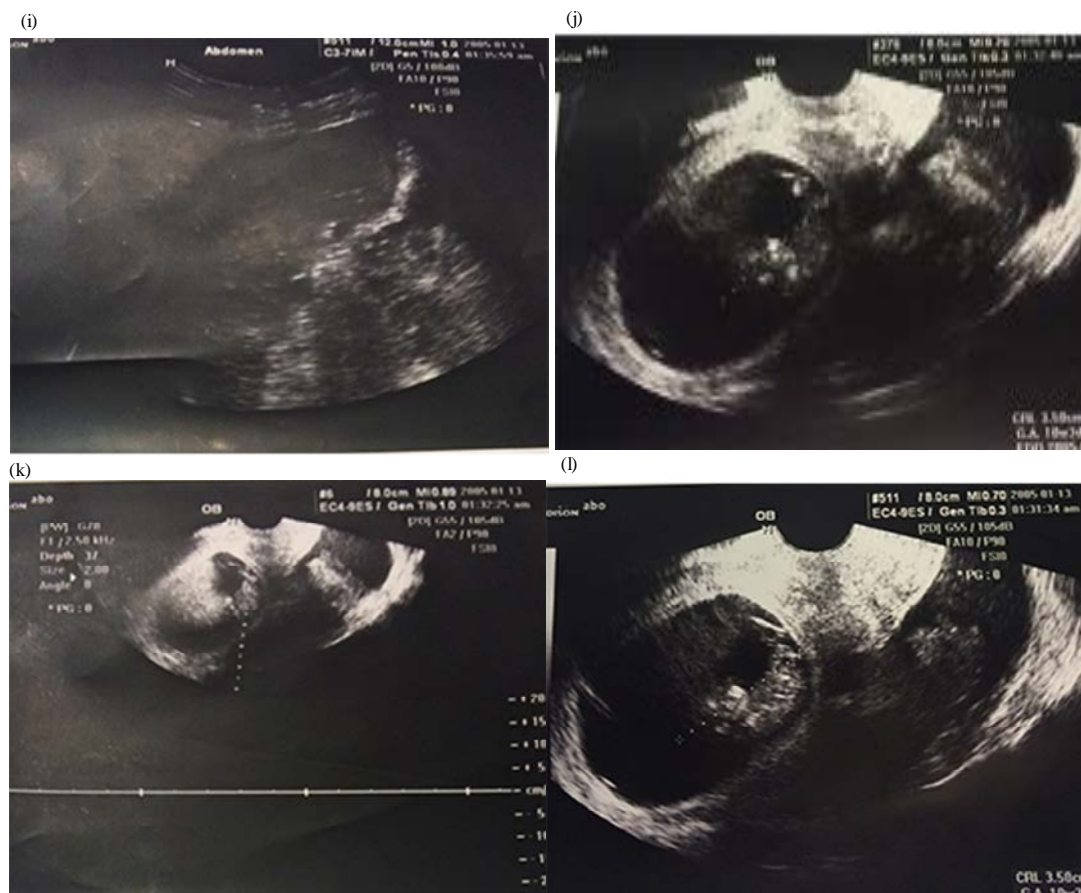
The sonographic images of pregnant women
